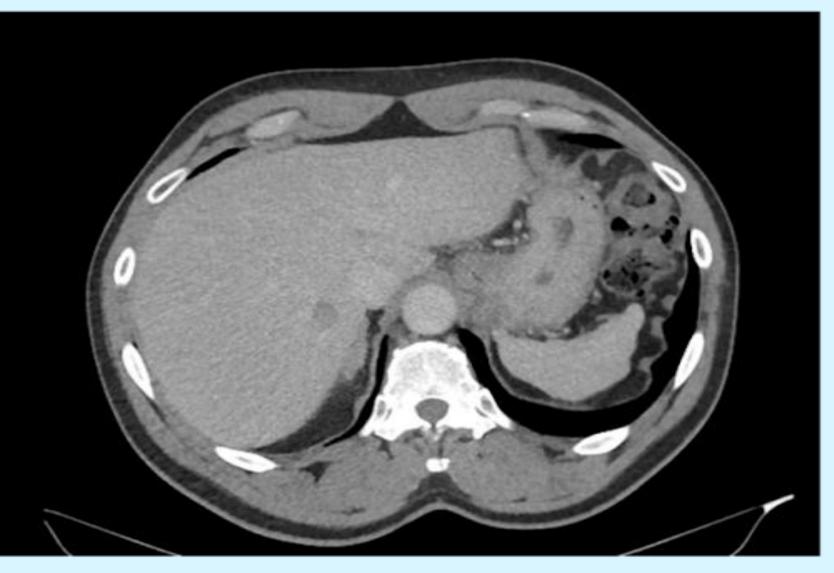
CT of Hypoechoic liver mass
